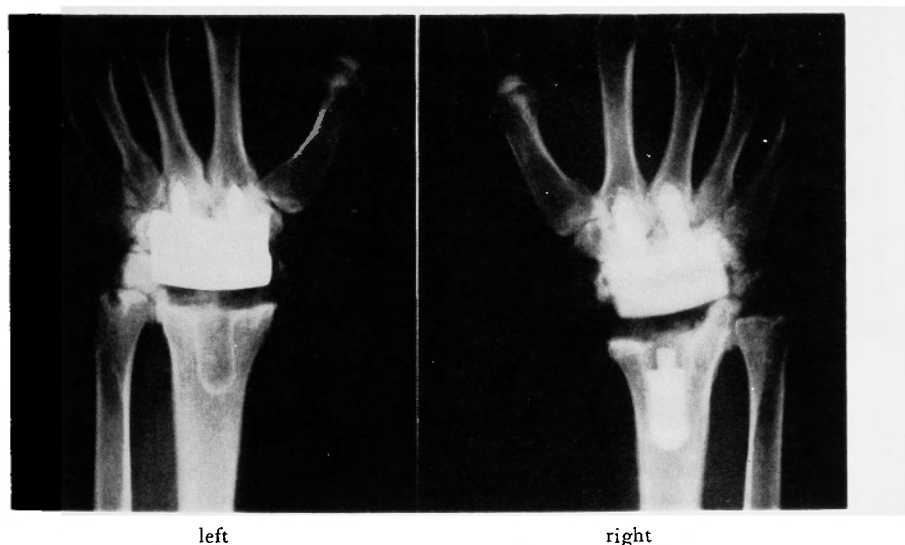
A postoperative radiograph showing both wrists replaced with prostheses.
